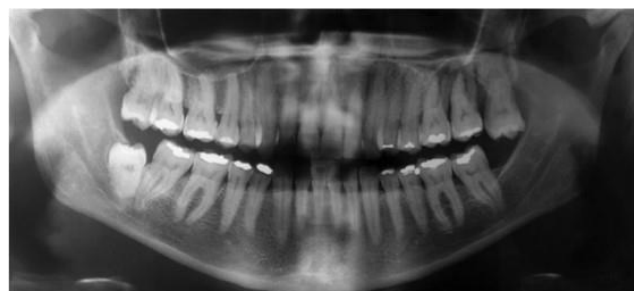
Panoramic radiography revealing the teeth 27 and 28 with advanced periodontal disease.
